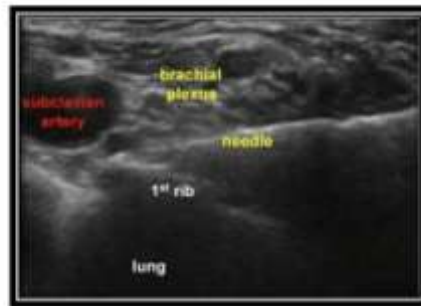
Ultrasonographic anatomy of Supraclavicular approach brachial plexus (with the visualization of the needle)
